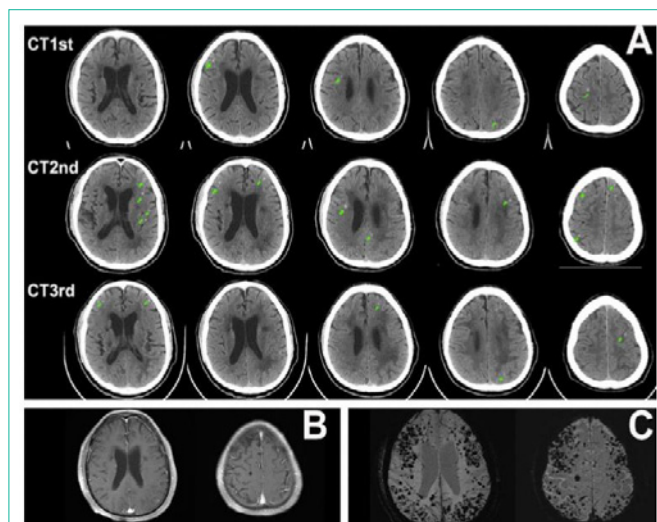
CT and MRI images of the brain.
